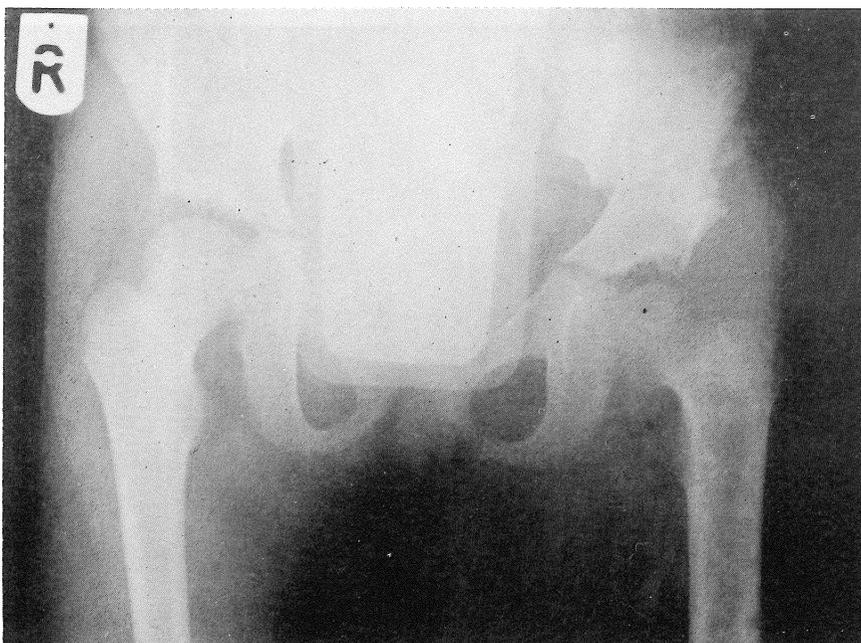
Post-operative radiograph six month after open reduction and varus derotation osteotomy with femoral shortening followed by a Salter osteotomy resulting in a Severin grade II hip.
